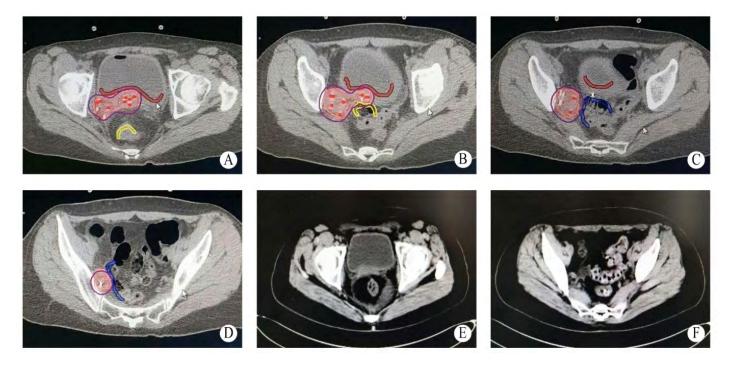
(A, B, C, D) Dose distribution of interstitial brachytherapy on CT image. The red dose line is 7Gy. (E, F) Two months after radiotherapy on CT image. The tumor disappeared completely.
